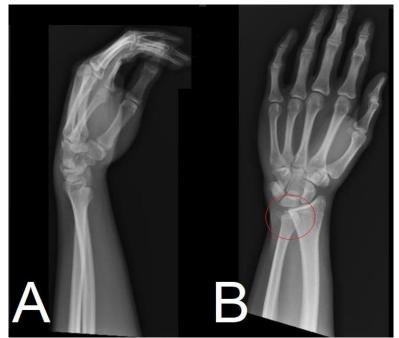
Lateral (A) and Posteroanterior (B) radiographs at initial presentation
